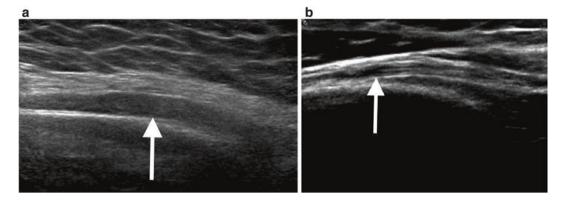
(a) Ultrasound demonstrates diffuse thickening of the radial nerve within the mid-arm. (b) Normal sonographic appearance of the radial nerve in a different patient
